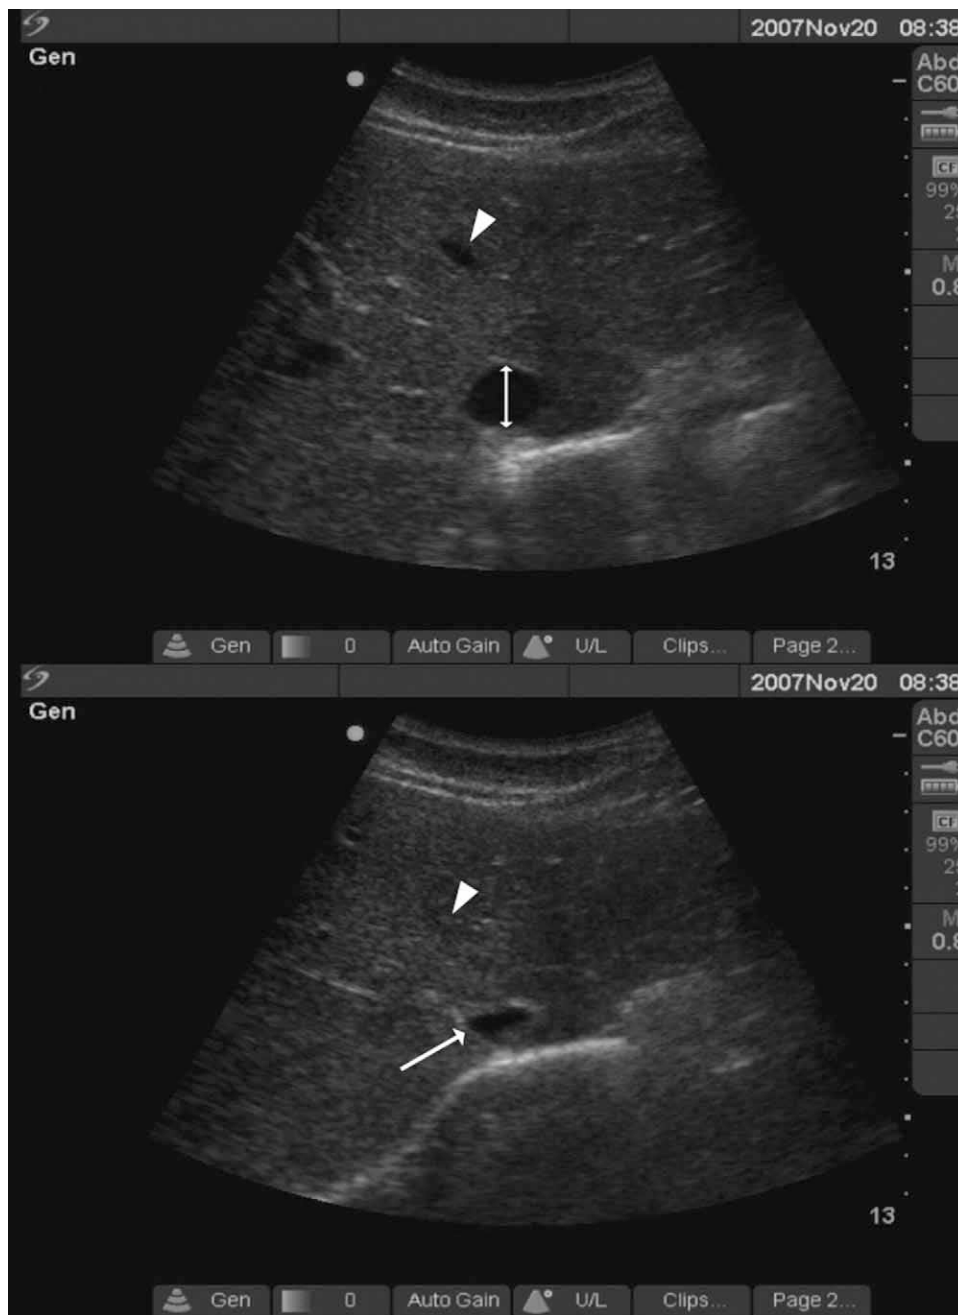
Inferior vena cava diameter changes with respiratory cycle. Inferior vena cava imaged in the same patient without movement of the ultrasound probe. The top image demonstrates maximum AP diameter during expiration with measurement taken as demonstrated by the arrow. Hepatic veins are also seen in this view (arrowhead). The bottom image shows collapse of the IVC (arrow) during inspiration, which has also led to collapse of hepatic veins (arrowhead).
